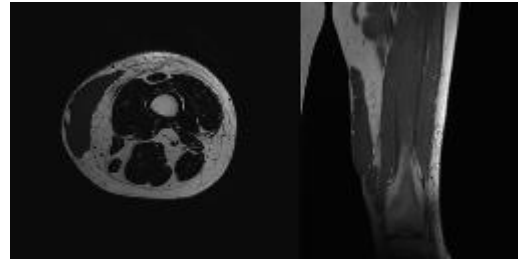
MRI image of the first patient. In the T1 MRI image, a well-defined fluid signal lesion measuring approximately 11x20 cm was observed in the subcutaneous layer of the left medial thigh.
